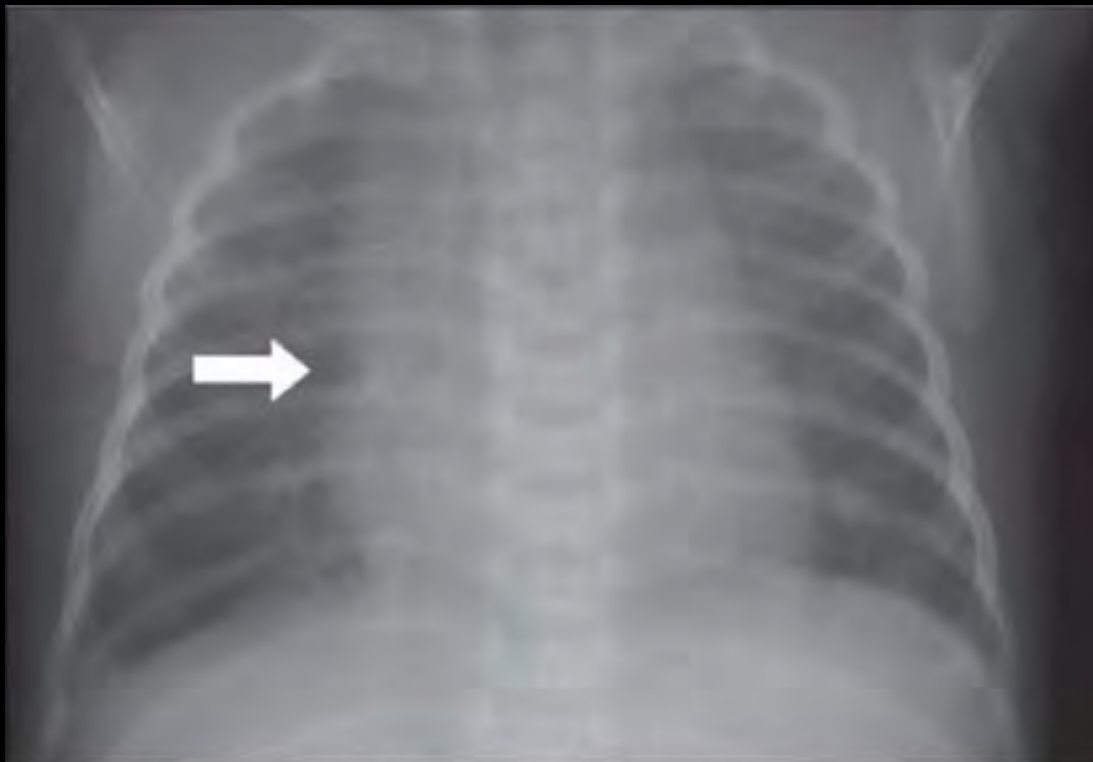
Twenty-two-day-old newborn infant x-ray demonstrating “notch-sign” (arrow).
